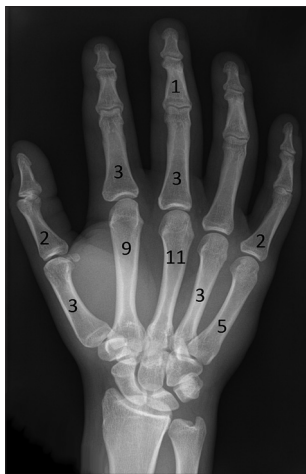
X-ray of hand anteroposterior view showing topographic distributions of the 42 fractures in 34 patients
